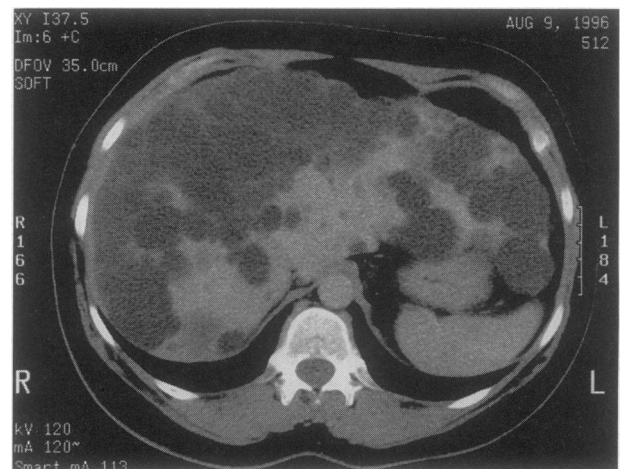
A patient with PCLD. CT scan reveals cysts throughout the whole liver and an absence of renal cysts. A right-sided hepatectomy and deroofing of the residual cysts resulted in a satisfactory outcome.
